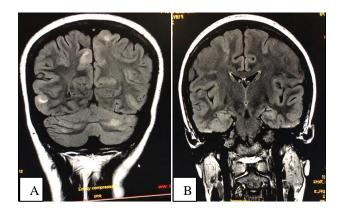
MRI brain FLAIR sequence showing hyperintensities in (A) bilateral fronto-parietal lobes and (B) cerebellar hemispheres.
